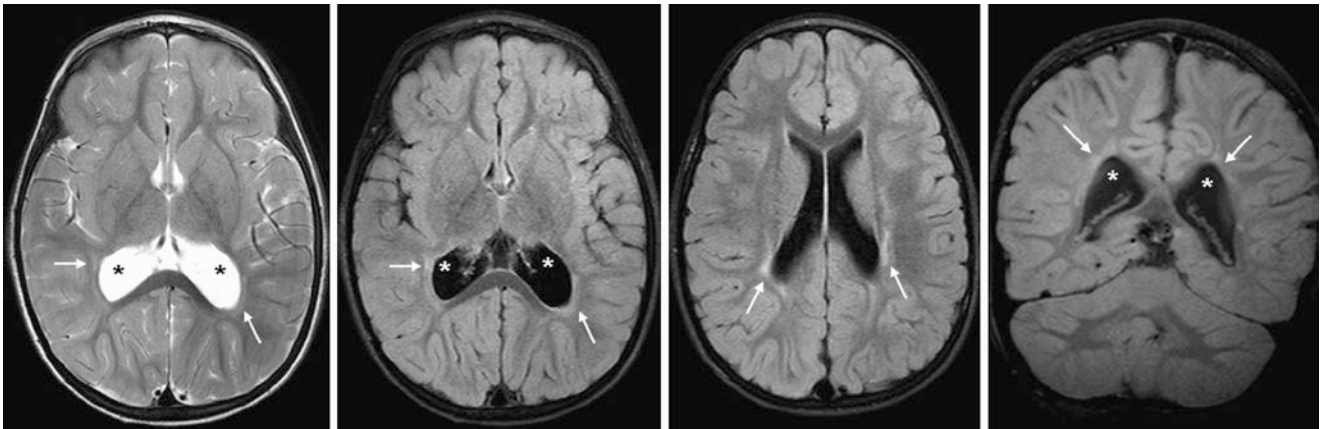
Comparison case of periventricular leukomalacia (PVL)-related dilatation of the atria of the lateral ventricles. The patient was a 3 year old with developmental delay, abnormal gait, and spastic diplegia born premature at 29 weeks' gestational age. There is cyst-like enlargement (*) of the atria of the lateral ventricles on a 3 T MRI with axial T2WI (*left*), FLAIR (*left middle and right middle*), and coronal
